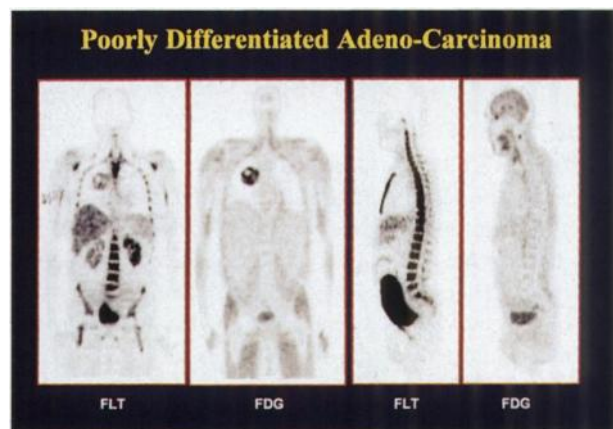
FDG and F-18 fluorodeoxythymidine imaging in poorly differentiated adenocarcinoma .
